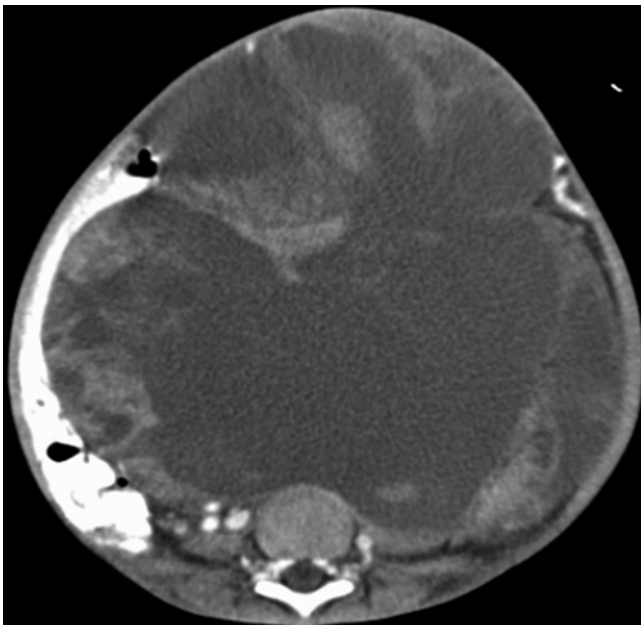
Transverse CT image of patient with typical triphasic Wilms' tumour. The displacement of the common iliac vessels to the right of the lumbar spine can be clearly seen
